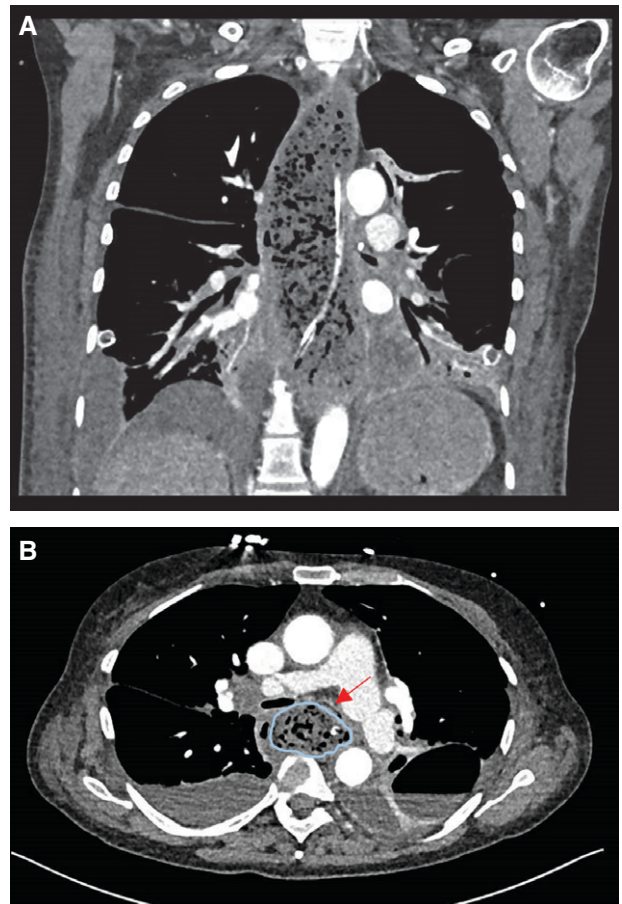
Thoracic computed tomographic images revealing esophageal impaction and bronchotracheal compression 26 days after transplantation. (A) Coronal image showing the extent of esophageal impaction. (B) Transverse image showing bronchial obstruction caused by the esophageal mass effect. The red arrow indicates the compressed left main bronchus. The blue circle indicates esophageal impaction.
